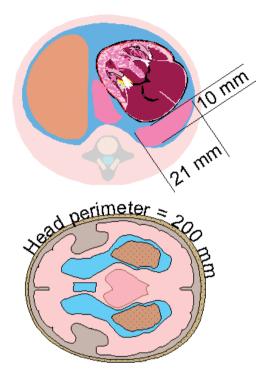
Calculation of lung: head ratio from 2D ultrasound. (From: 2000-05-29-17 Diaphragmatic hernia © Novakov www.thefetus.net).
